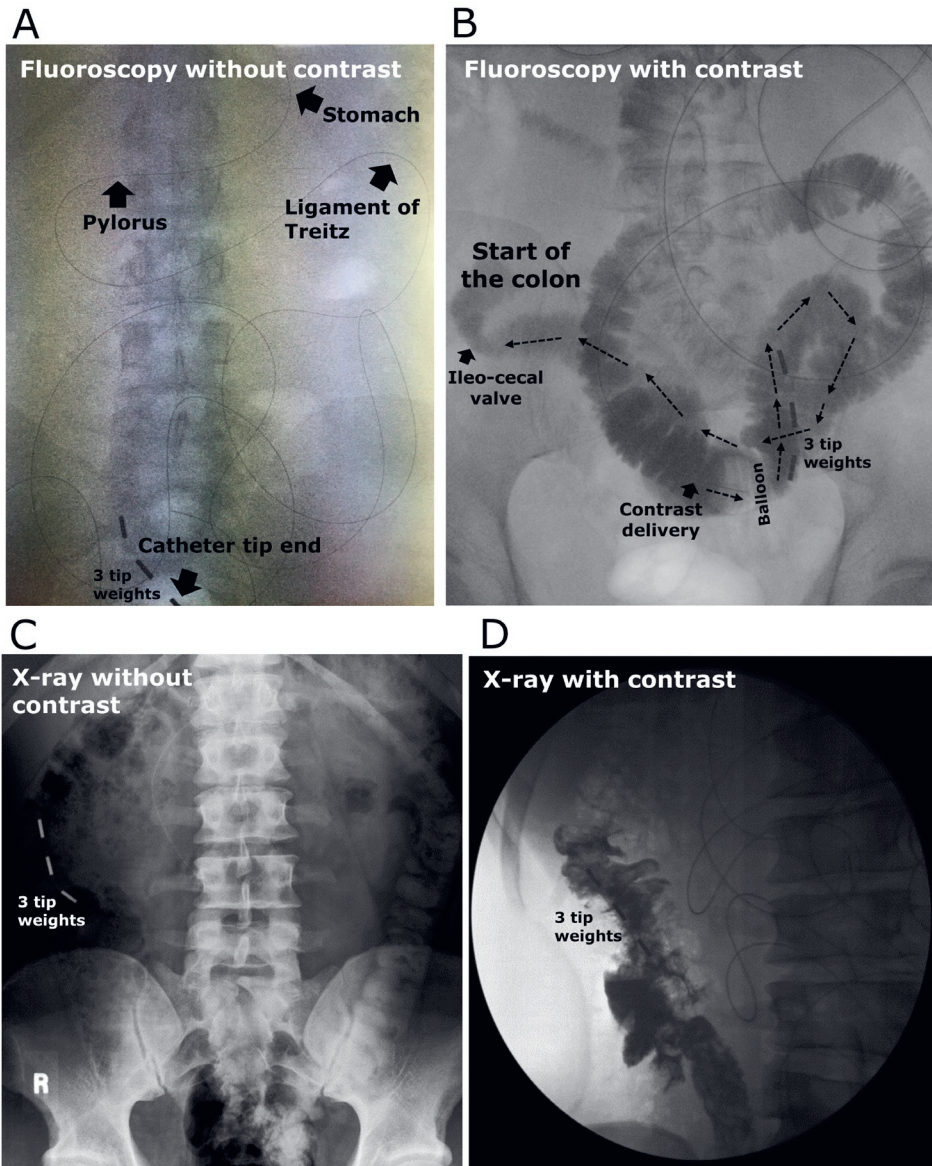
Examples of visualization of the catheter tip location using fluoroscopy or X-rays with/without the delivery of contrast liquid in human subjects.
